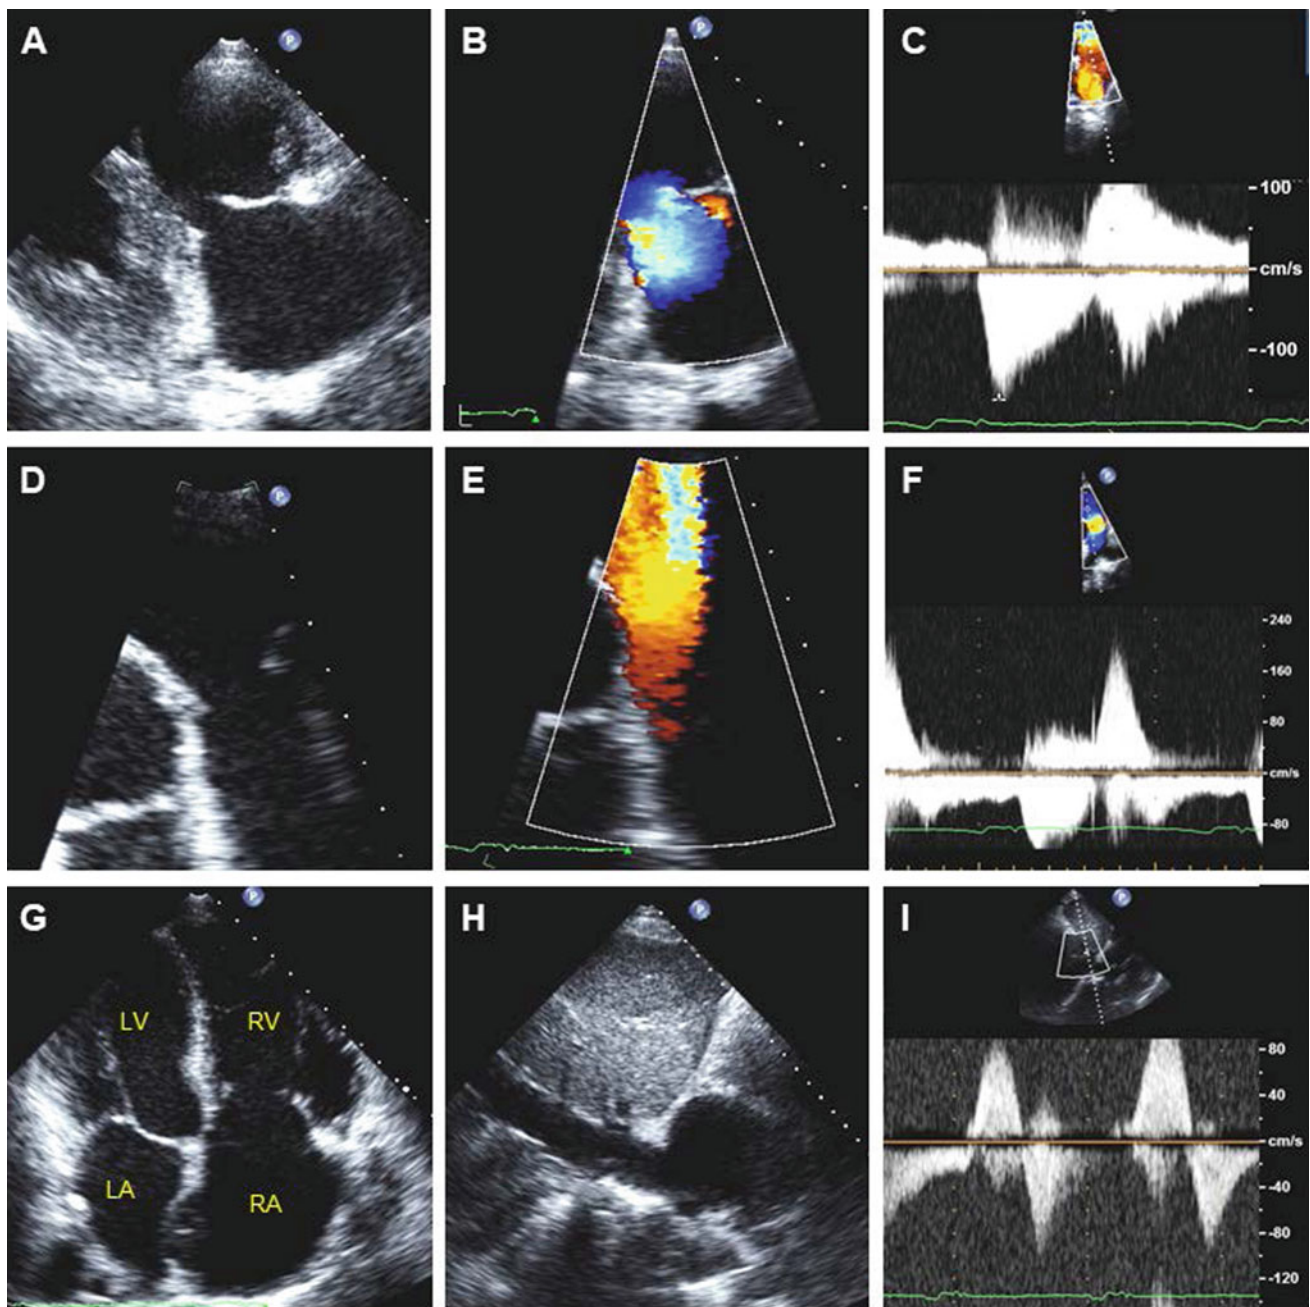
Classic findings of carcinoid heart disease. There is thickening, retraction, and immobility of the tricuspid (A) and pulmonary (D) valves. The coaptation gaps are so wide that the resultant jets of severe TR (B) and PR (E) appear laminar by color Doppler. Dense, triangular-shaped CW Doppler profiles across the tricuspid valve during systole (C) and across the pulmonary valve
